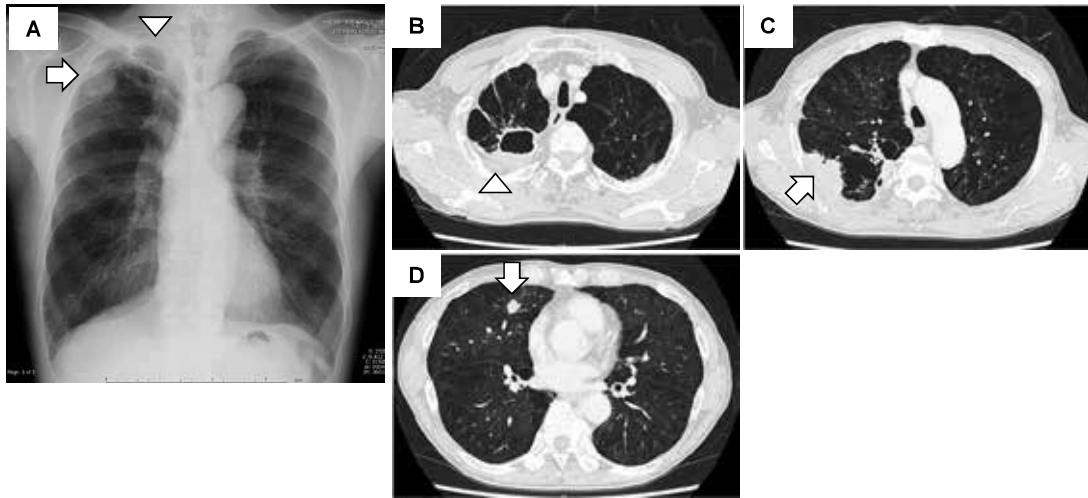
Images of chest X-ray and chest CT scan on admission. A chest X-ray revealed a cavitation with pleural thickening and a mass in the right upper lung field (A). A chest CT scan showed a cavity with a thick wall in the right apical region (B), a mass adjacent to the pleura in the right upper lobe (C), and a nodule in the right middle lobe (D). Arrowheads and arrows indicate the locations of pulmonary *M. heckeshornense* infection and lung adenocarcinoma, respectively.
